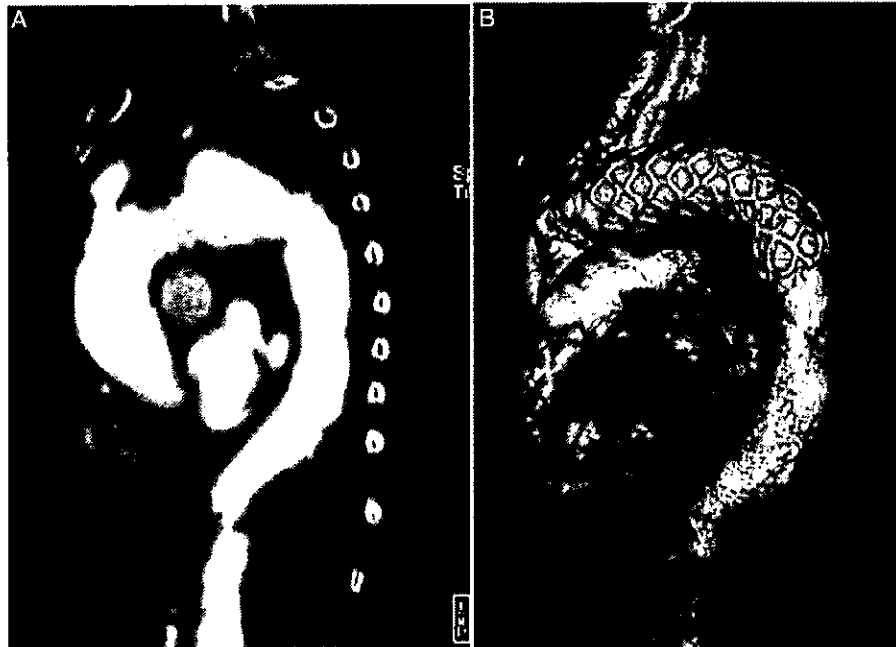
Preoperative CT image and postoperative CT image. The stent graft was evaluated 6, 12 and 24 months after the operation, by means of CT. Compared with the Z stent graft, the open stent graft shows favourable trackability to the curved aortic arch. (A) Preoperative, (B) postoperative.
